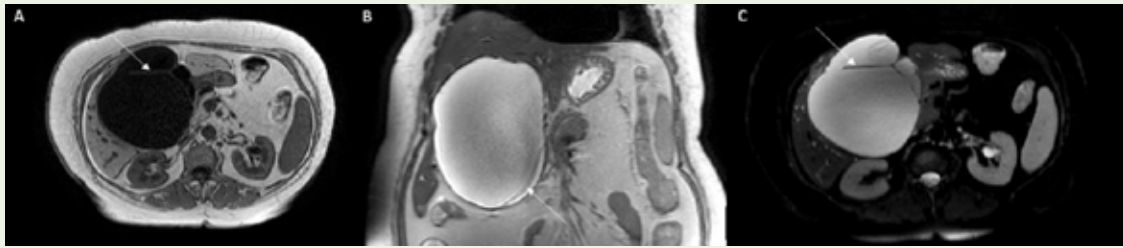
Case of a 56-year-old female with abdominal pain: T1-weighted axial section (Image A) and T2-weighted coronal (Image B) and axial (Image C) section respectively of MRI abdomen reveals a well-defined partially exophytic well-defined T1-hypointense and T2-hyperintense lesion showing few T2 hypointense septae (marked by white line arrow) within (WHO stage CE-2 or Gharbi type III).
